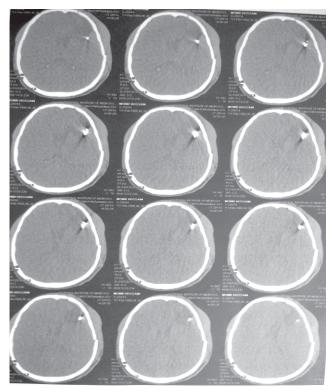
CT scan of brain showing clip
